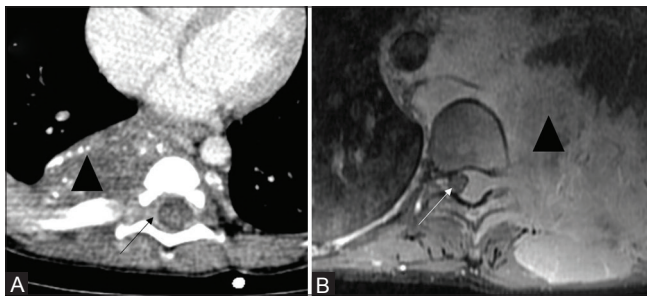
(A and B): Mere intraspinal extension is not an IDRF. Image A is an axial CT section showing a right paravertebral mass with intraspinal extension (arrow) that occupies less than 1/3rd of the spinal canal (L1) while Image B is an axial post-contrast MRI that reveals a left paravertebral mass that extends into the spinal canal and displaces the cord to the right side (arrow) with obliteration of lepto-meningeal space (L2)
